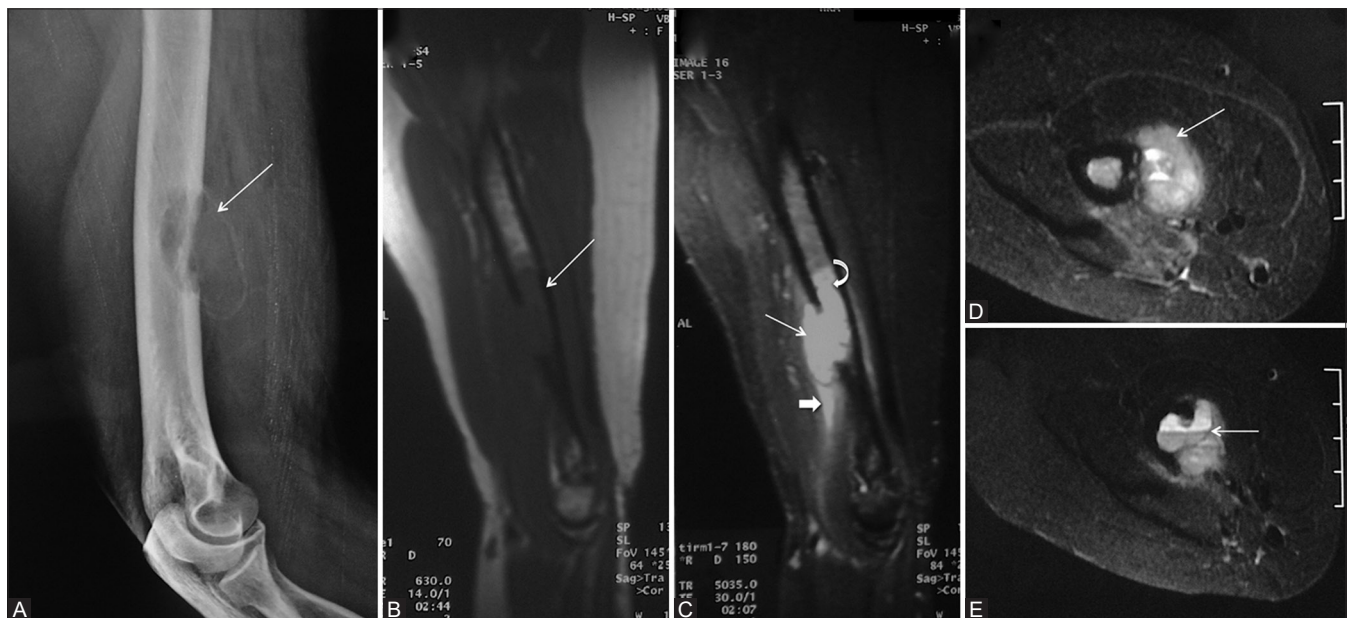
(A-E): A 50-year-old female with swelling in the right forearm (Case 1). (A) Lateral radiograph of arm including elbow showing expansile, eccentric, cortical-based lytic lesion with thin shell of cortex in lower diaphysis of right humerus (arrow) B-D: Sagittal T1W (B), T2W fat saturated (C), Axial T2W fat saturated (D and E) MR images is showing lesion in lower end of humerus which is hypointense on T1W (arrow, B), hyperintense on T2W (arrow, C) associated with a soft tissue component (D) having blood-fluid levels (arrow, E) with extensive marrow (curved arrow, C) and soft tissue edema (block arrow, C)
